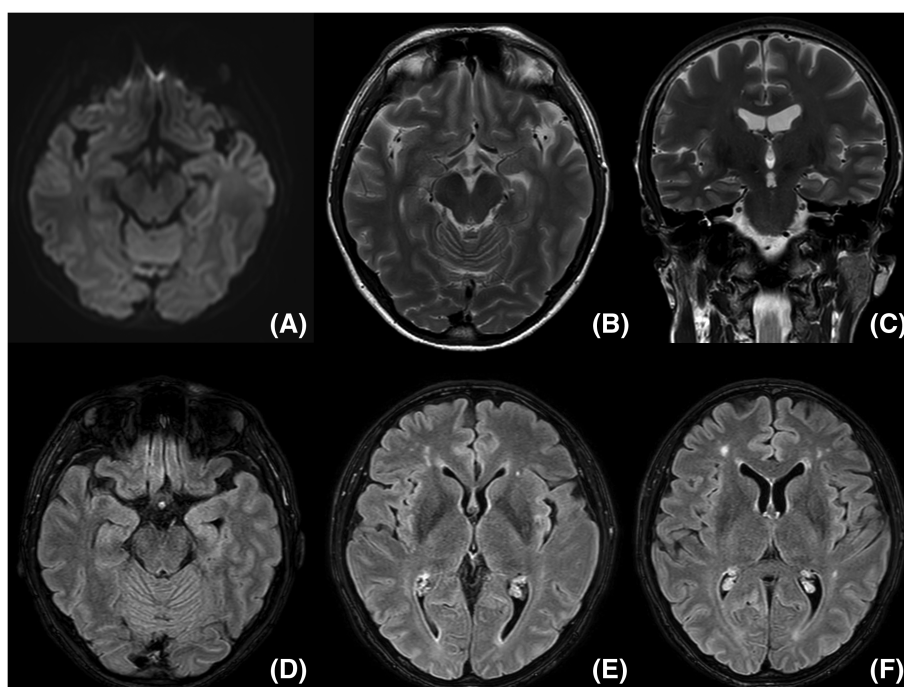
Magnetic resonance imaging (MRI) performed during the acute phase of TCC toxic encephalitis. (A) Axial diffusion weighted imaging (DWI), (B) axial T2 weighted scan, and (C) coronal T2 weighted scan of the brain did not show any abnormalities. (D), (E) and, (F) Fluid attenuated inversion recovery (FLAIR) scan of the brain showed non-specific bilateral periventricular hyperintensity
